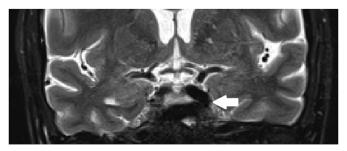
Magnetic resonance imaging in coronal view demonstrating bilateral, left greater than right, cavernous sinus carotid vascular ectasia, (white arrow).
